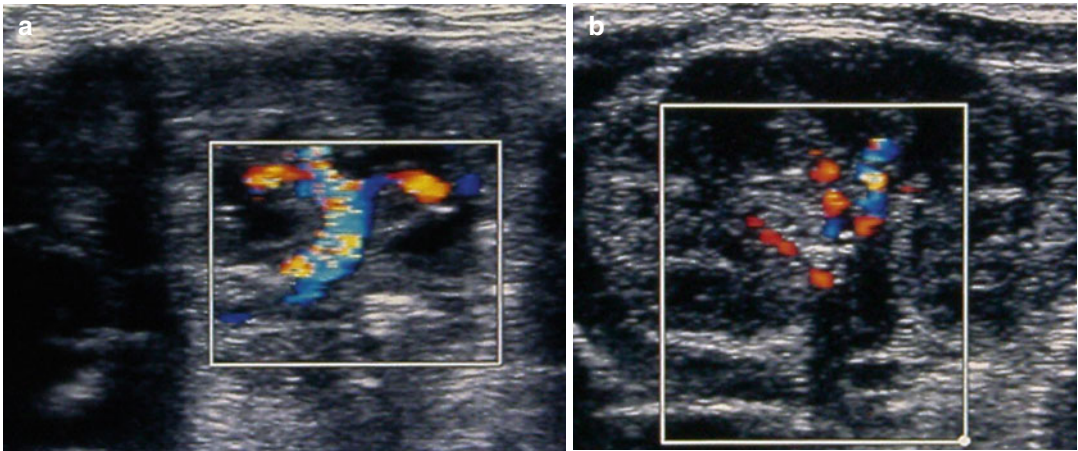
Color Doppler ultrasound. (a) Normal right renal vein. (b) Left renal vein thrombosis: the absence of color signal and the presence of echoes in the vessel
